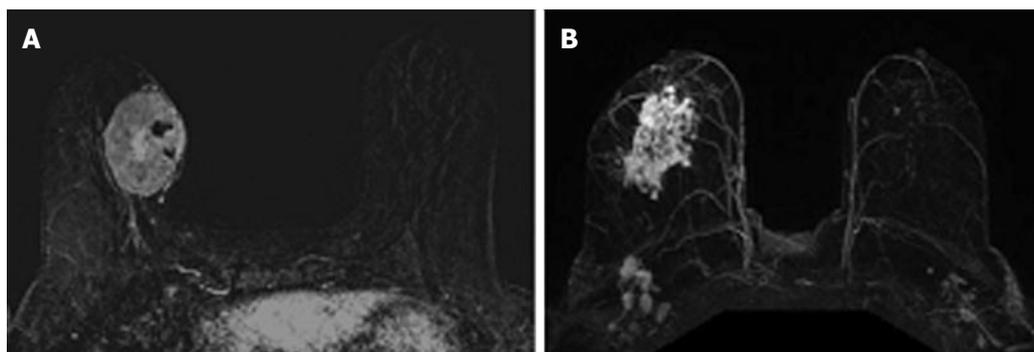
Magnetic resonance imaging phenotypes solid unifocal mass (A) and more diffuse non-mass enhancement (B).
